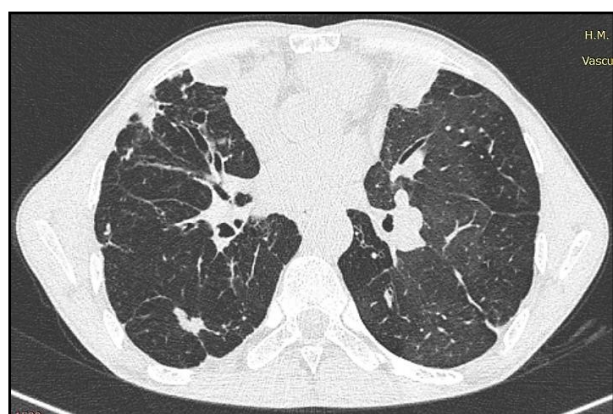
Chest CT scan in axial section and parenchymal window showing architectural disorganization with retractor lesions and pulmonary ventilation disorder.
